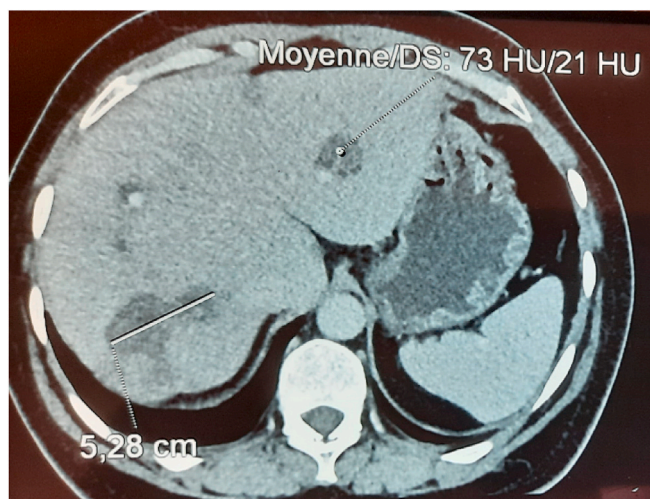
CT scan showing hypodense hepatic nodules involving both lobes with heterogeneous enhancement.
